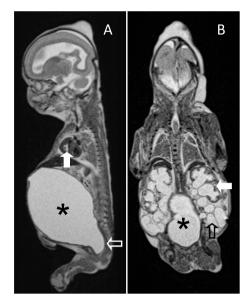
A neonate aborted at 20 weeks gestational age. a Antenatal US showed a massively dilated bladder and bilateral hydronephrosis. Sagittal T2-W MRI shows a distended bladder (asterisk) and a dilated posterior urethra (open arrow), consistent with posterior urethral valves (slice thickness: 1 mm, TR: 1500, TE: 161, FA: 150°). Note the fluid-fluid level in the heart (arrow) as a result of clotting blood. Figure 9b. Coronal T2-W MRI shows a distended bladder (asterisk) and dilated tortuous ureters (open arrow). There is a valstantial bilateral pyelocaliceal dilatation (arrow). There is a relative hypoplasia of the lungs as a result of the oligohydramnion.
